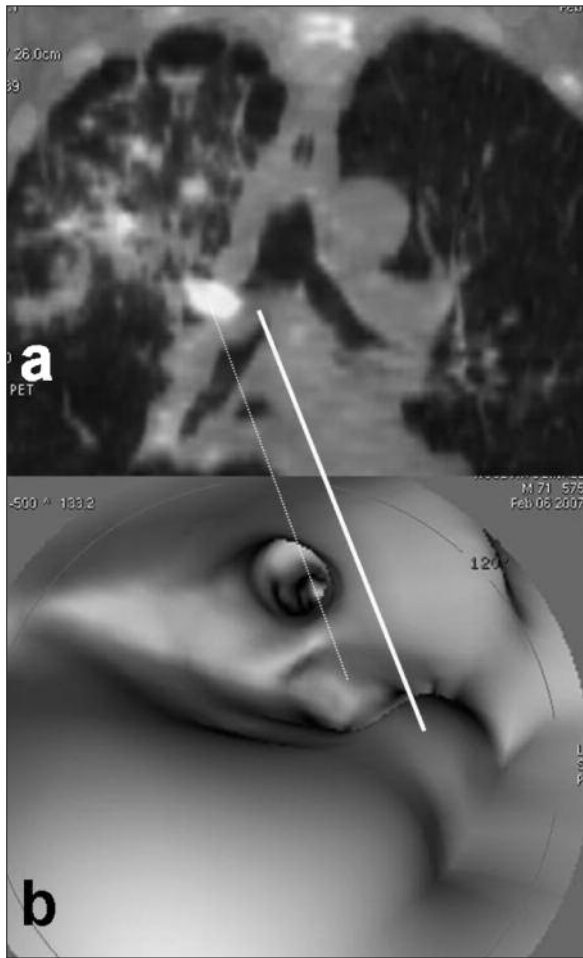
Evaluation of the characteristics of the segment involved by malignancy via VB under the guidance of FDG uptake over the fused images. *(a)* The soft tissue mass constricting the upper lobe bronchus shows FDG affinity, whereas the mass constricting the lower lobe bronchus, does not show any uptake. *(b)* It is observed that the lesion, which actually do not show FDG uptake on VB attracts more attention in various points of view (*thick line*). However, the pathology that requires biopsy on VB image (*dotted, thin line*) exists in another localization.
